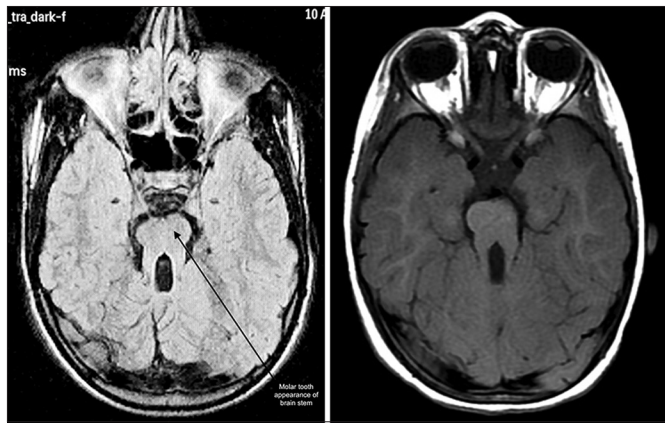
Axial T1-weighted images showing the “molar tooth sign”
